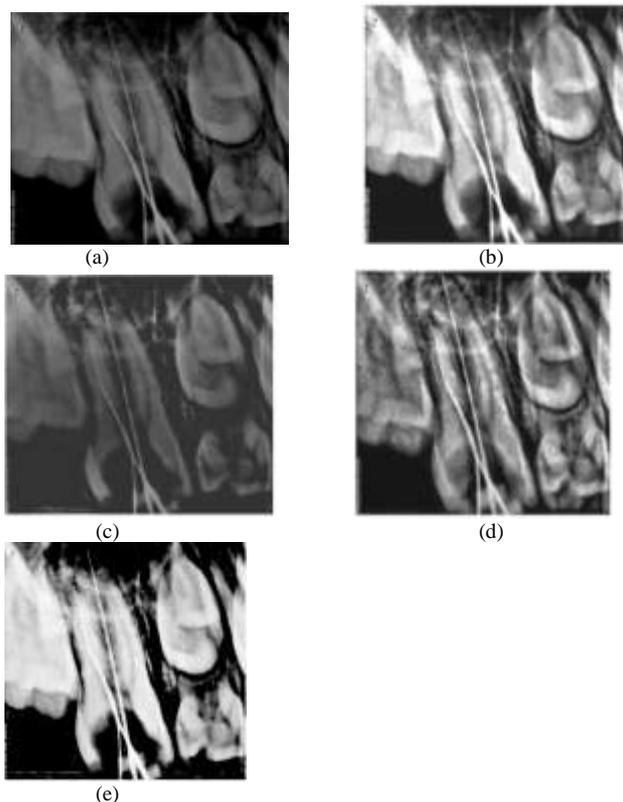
(a) Roots superimposed CBCT input image (b) Output image after Histogram (c) Output image after CLAHE (d) Output after MSR (e) Output after Fuzzy enhancement.
